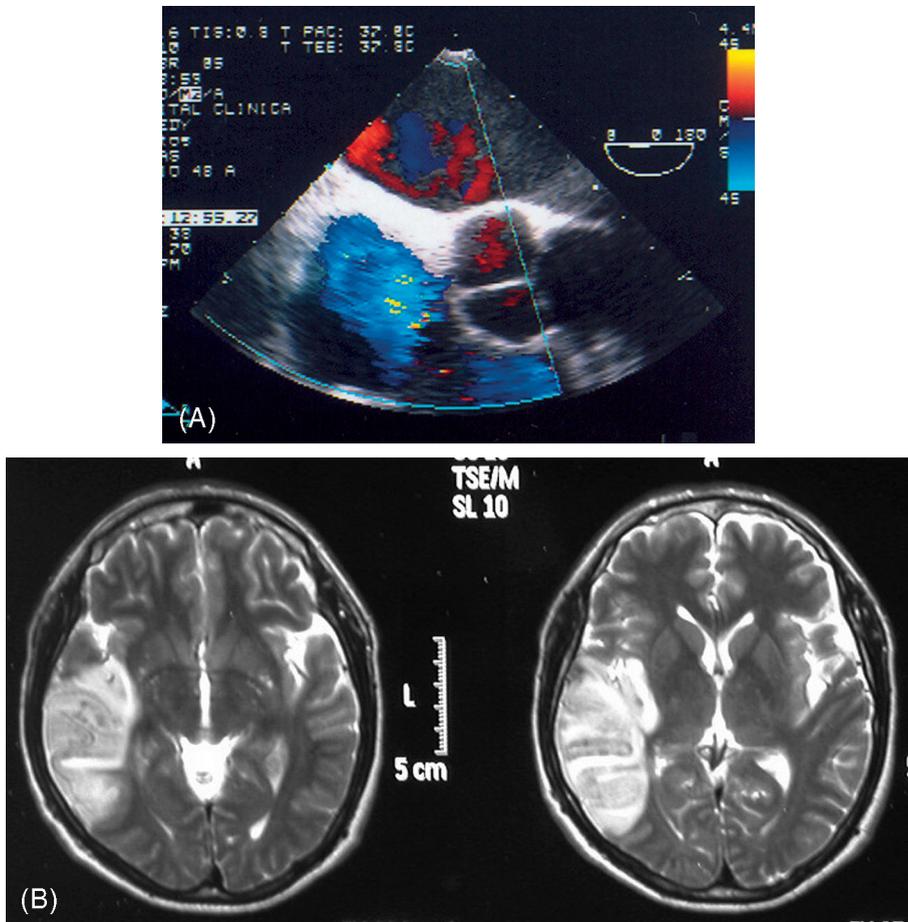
Transthoracic echocardiogram showing dilated cardiomyopathy (A), and T2-weighted showing cortical infarction in middle cerebral artery territory (B) in patient with chronic Chagas' disease.
